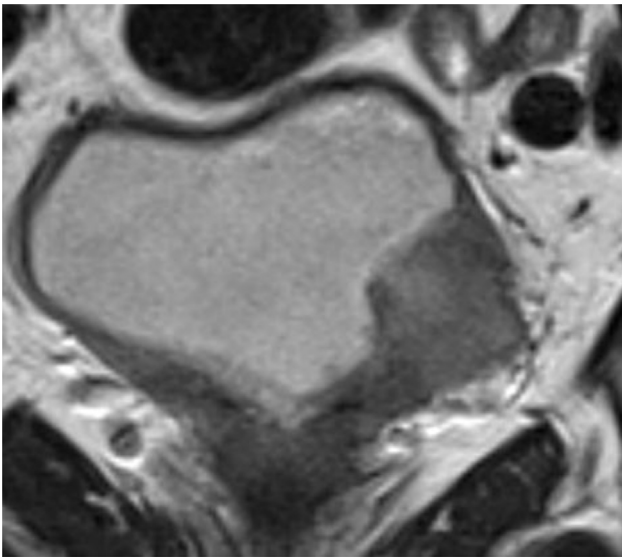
Coronal T2-weighted magnetic resonance imaging (MRI) of the bladder showing a 2.2 × 2.4 cm solid tumor on the left side with an extravesical mass.
